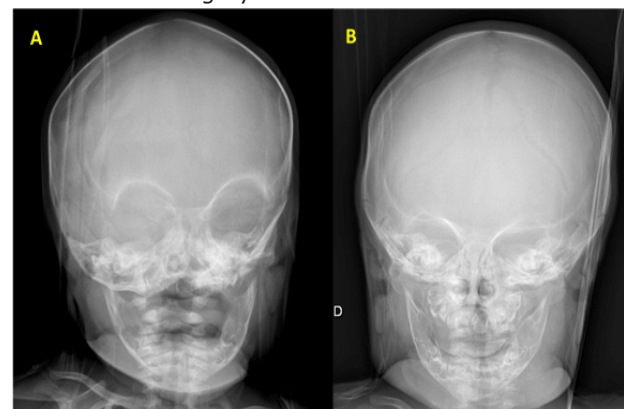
Skull radiography after surgical elevation of the parietal bone. A. - One week after surgery. B. - Two months after surgery.
